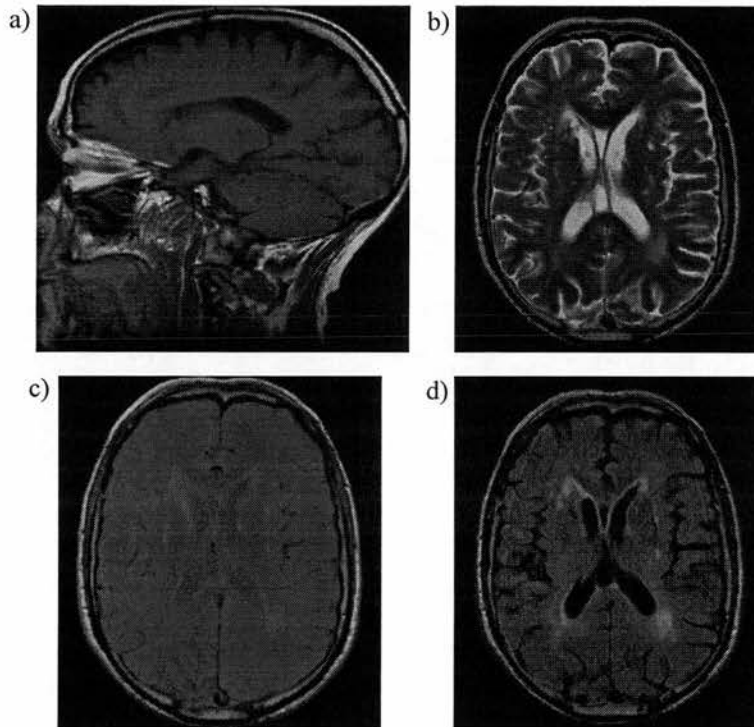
Examples of the different types of image contrast possible using MRI techniques showing; a) T_1 -weighted sagittal image; b) T_2 -weighted axial image; c) Proton density axial image; and d) inversion recovery CSF-suppressed FLAIR image.
